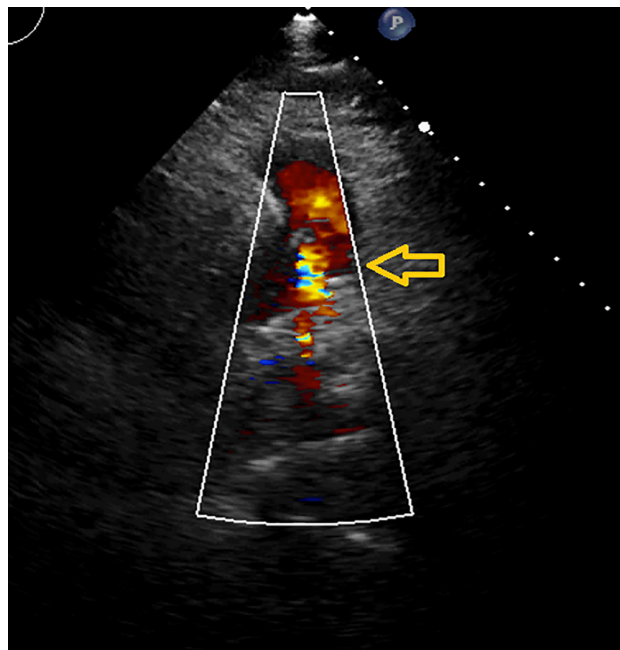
5-2D Echocardiography of the Stenosis Site in the Second Patient after the Intervention
